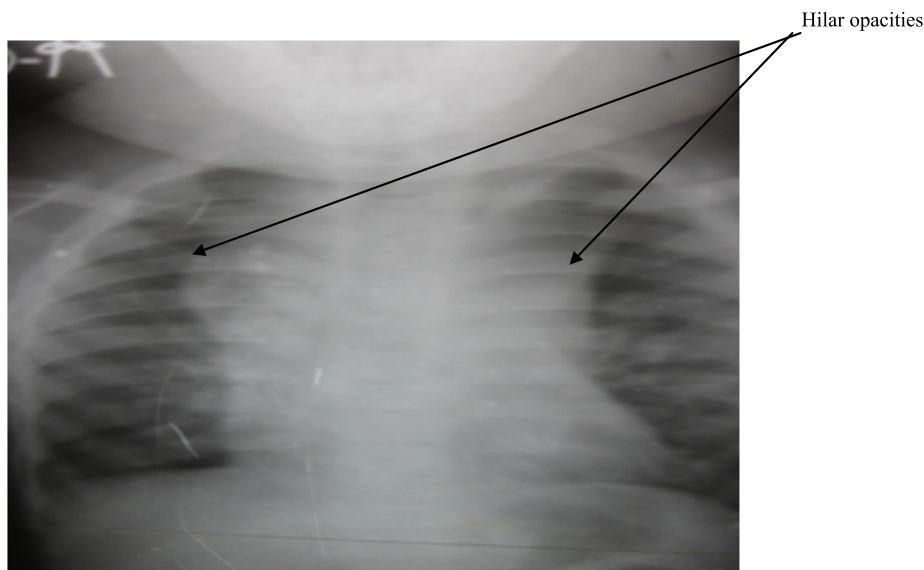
Chest X-ray of a 4 year old boy diagnosed of Pulmonary TB showing Hilar fullness (opacities), with convex outer margin on the right.
